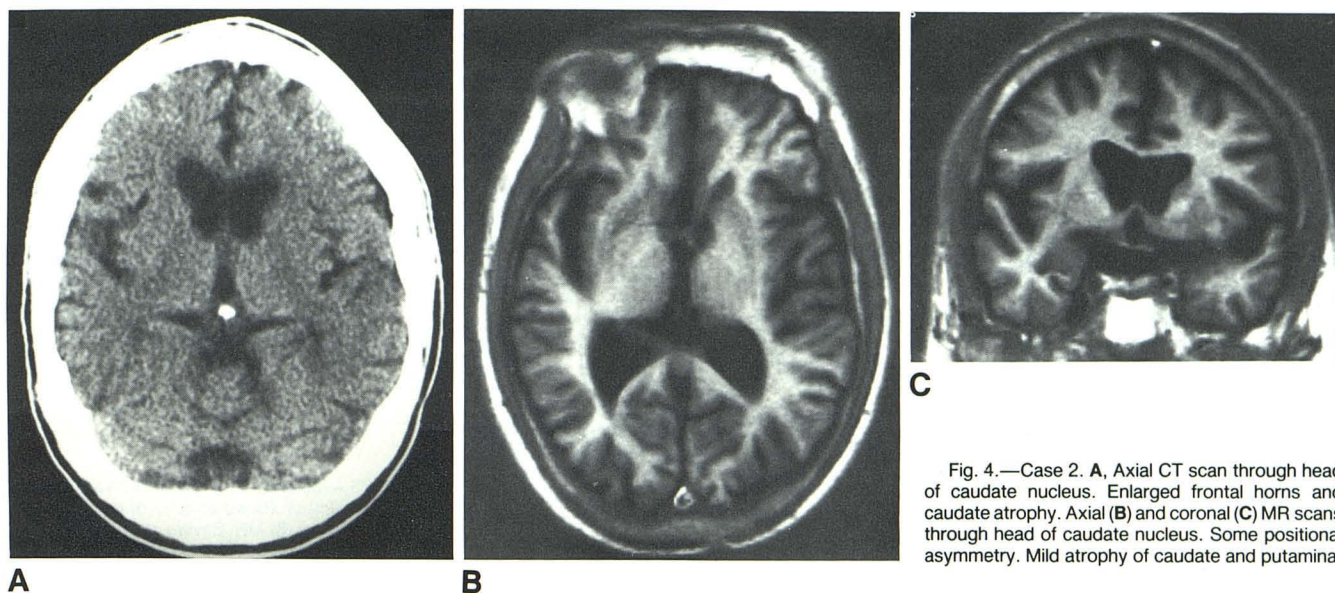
Case 2. A, Axial CT scan through head of caudate nucleus. Enlarged frontal horns and caudate atrophy. Axial (B) and coronal (C) MR scans through head of caudate nucleus. Some positional asymmetry. Mild atrophy of caudate and putamina.
